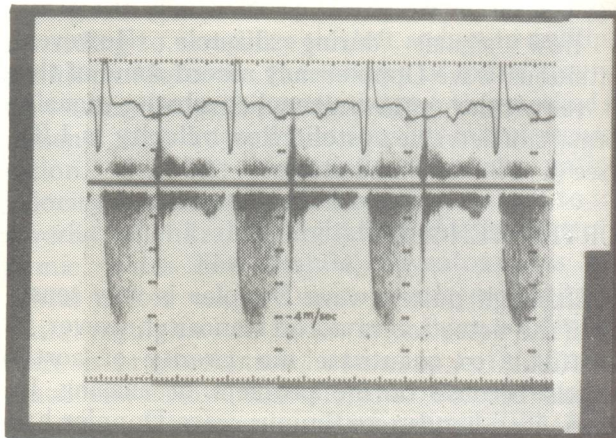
Doppler tracing recorded from the apical view in a patient with aortic stenosis. The peak velocity across the aortic valve is 4.2 m/sec with a peak instantaneous gradient of 71 mm Hg.
